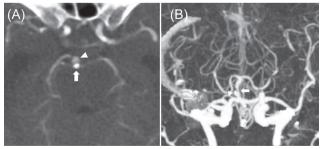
Computed tomography angiography (CTA) shows a true lumen (arrow) and a false lumen (arrowhead) with an intimal flap (or double lumen sign) (A). A wide neck pseudoaneurysm formation (arrowhead) in middle one-third portion of basilar artery, anterior superior orientation, with distal focal stenosis (arrow) (B).
